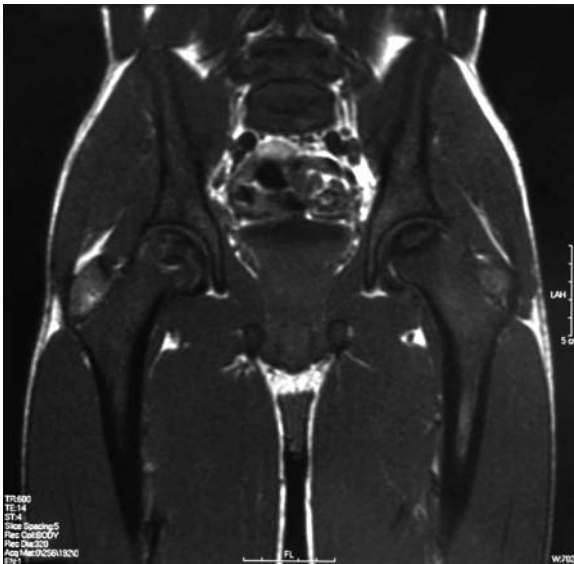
Marrow evaluation with MR T1-weighted image of the pelvis in a 10-year-old with sickle cell anemia demonstrates diffuse myeloid hyperplasia. The marrow should be bright, but instead it is diffusely dark, including the epiphysis
